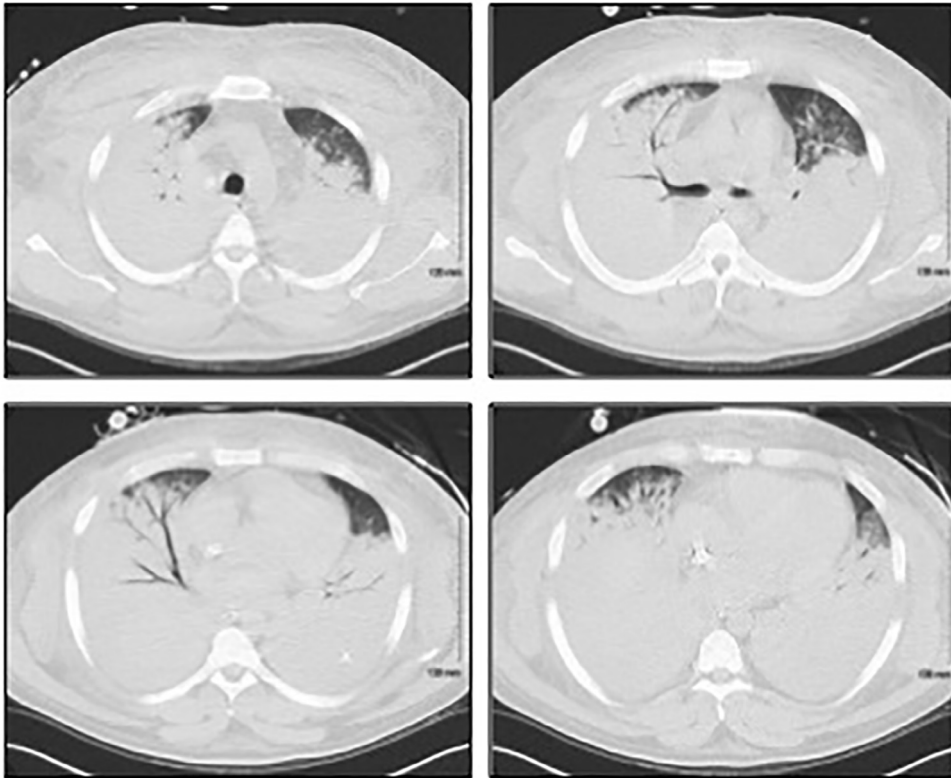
A CT scan of the chest performed 24 hours after ECMO cannulation demonstrating diffuse pulmonary edema.
